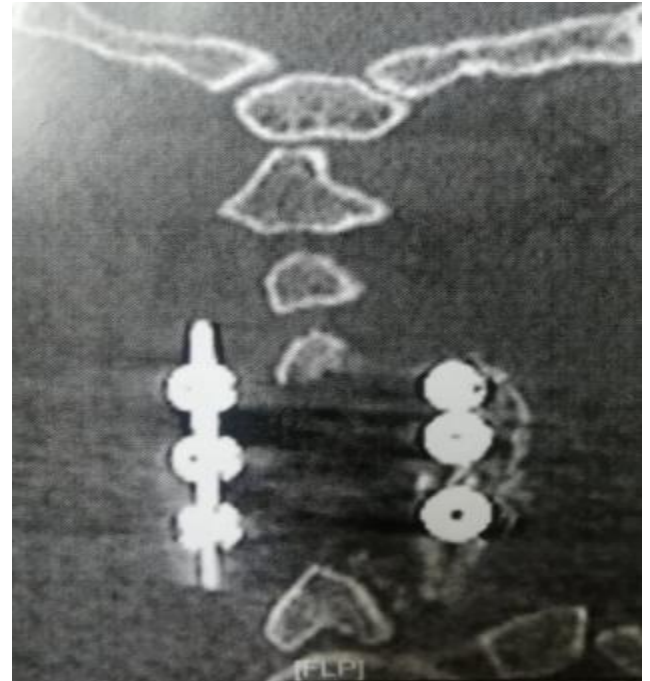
Postoperative CT cervical spine (coronal view) showing 6 lateral mass screws with the rod system accompanied with laminectomy to decompress and fix cervical spine in 55 years old myelopathic female.
